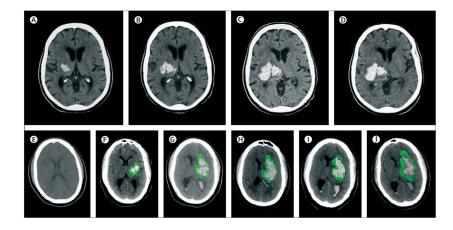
Progression of haemotoma and oedema on CT
